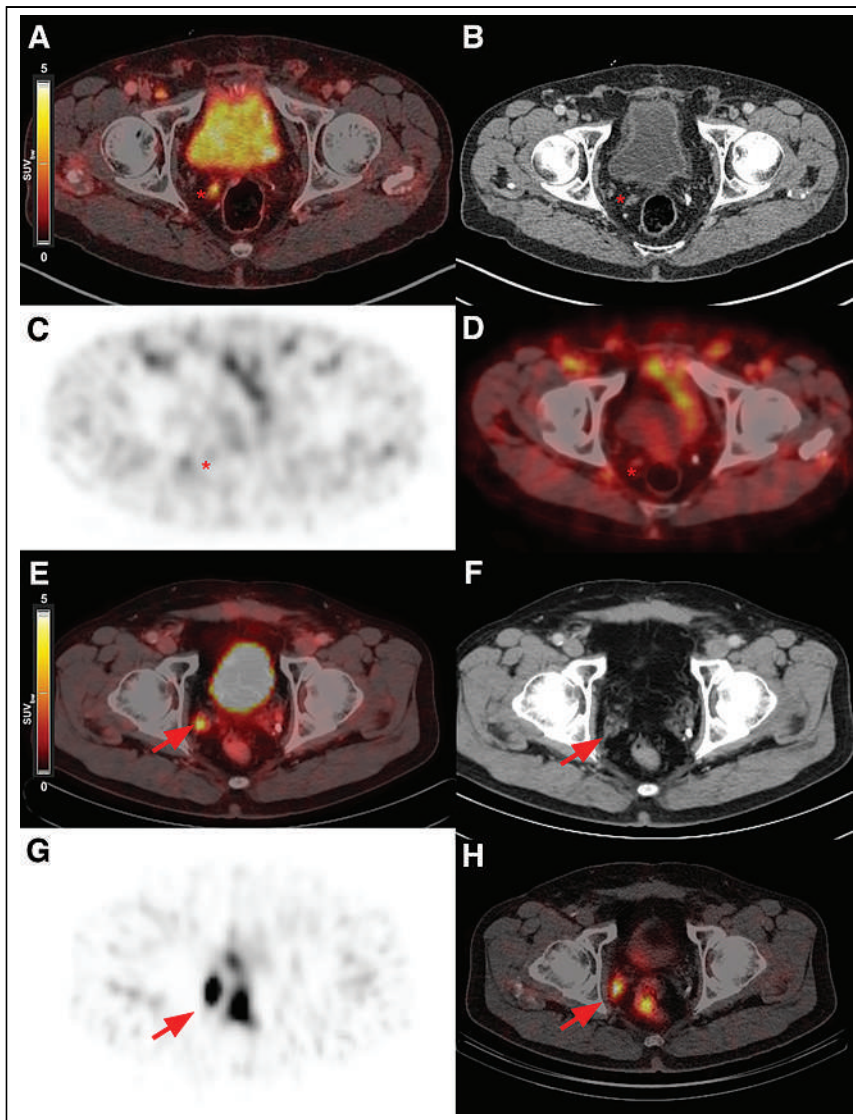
Examples of early (A–D) and late (E–H) [^{99m}Tc]Tc-PSMA-I&S SPECT/CT imaging. (A–D) In 74-y-old patient who had RP in 2004 and BCR in 2016 (PSA, 0.66 ng/mL), PSMA PET (A and B) shows local recurrence in right prostate fossa with intense PSMA expression (SUV_{max}, 12.7 [asterisk]); 4 h after [^{99m}Tc]Tc-PSMA I&S injection, SPECT/CT (C and D) morphologically identifies known local recurrent cancer (asterisk) but uptake is not above background, with overall score of 2. (E–H) In 66-y-old patient who had RP in 2012 and BCR in 2018 (PSA, 0.59 ng/mL), PSMA PET (E and F) shows right internal iliac lymph node metastasis with intense PSMA expression (SUV_{max}, 5.0 [arrow]); 18 h after [^{99m}Tc]Tc-PSMA-I&S injection, SPECT/CT (G and H) confirms metastasis with significant uptake above background (score 4, arrow).
